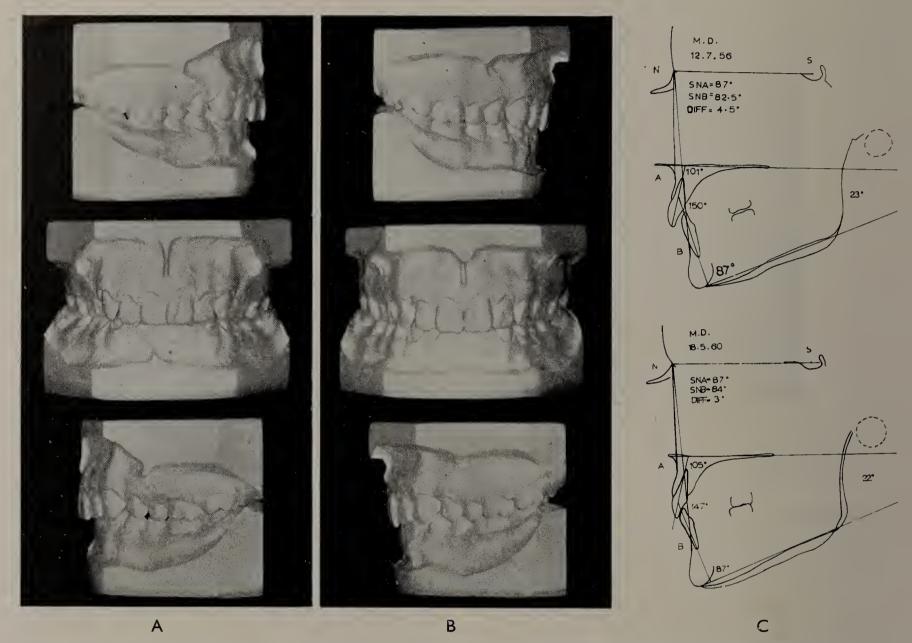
A, Models of a boy with a Class II, division 2 malocclusion. The mandible was post-normal; B, Occlusion four years later, nine months out of retention. The upper buccal teeth were moved distally with extra-oral traction. No teeth were extracted. C, Lateral X-ray tracings.
